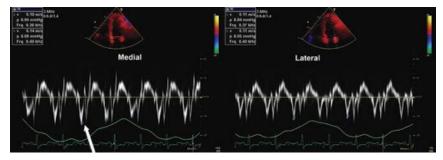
CP: PW Doppler tissue imaging from the apical four-chamber view in a patient with CP. Measurements of the peak e' from medial and lateral annulus should be obtained. Note in this example that the medial e' (arrow) is elevated (14 cm/sec) and greater than than the lateral e'. This finding (annulus reversus) is a typical feature of CP when the lateral annulus is involved with the constrictive process.
